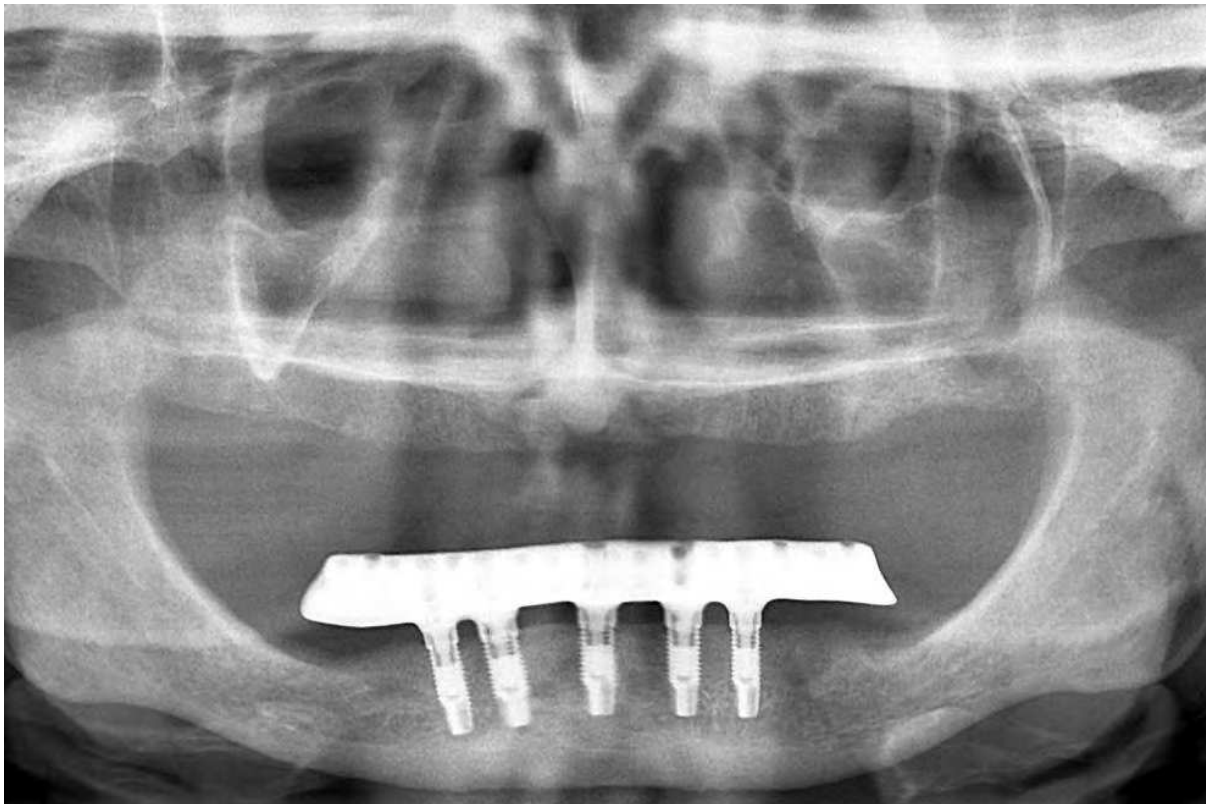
Panoramic radiograph of the patient a year after the implant placement.
